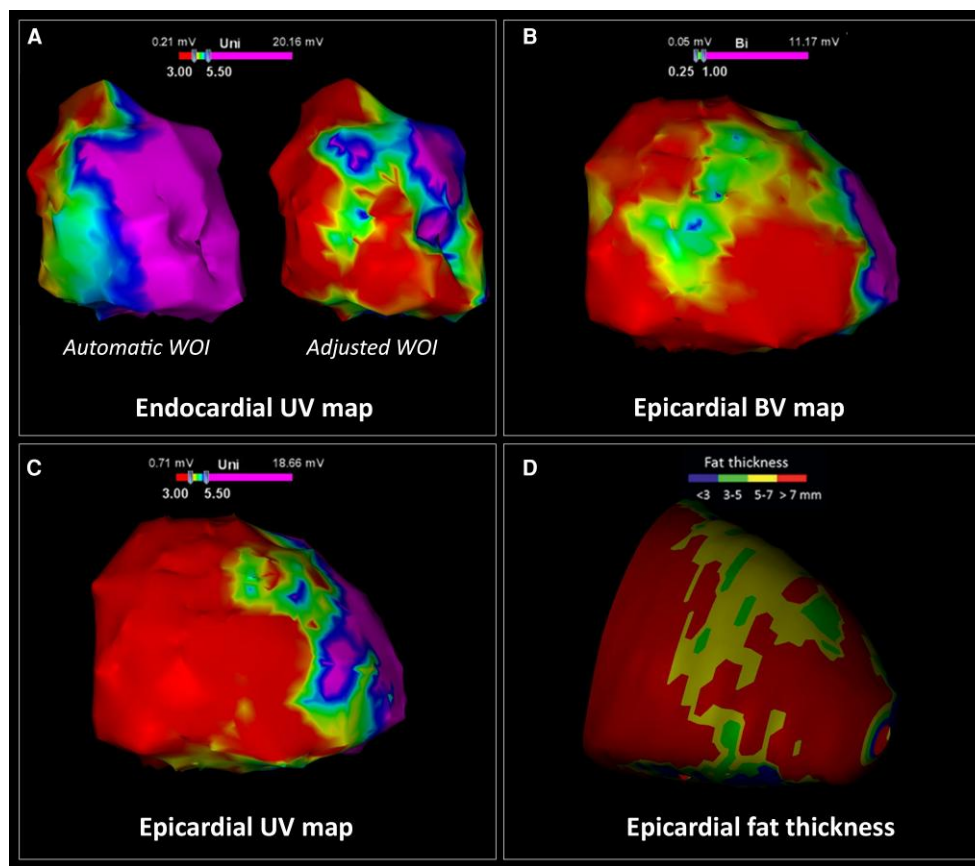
Example of the importance of adjusting the WOI and the role of epicardial UV mapping. Endocardial and epicardial mapping during RV pacing in a patient with arrhythmogenic right ventricular cardiomyopathy in modified right anterior oblique view. (A) Endocardial UV map using the automatic WOI on the left and the UV map after adjusting the WOI on the right, clearly demonstrating the underestimation of scar using the automatic WOI. (B) Epicardial BV map. (C) Adjusted epicardial UV map. (D) Epicardial FT map, based on CT. Notable, UV (see C) is less influenced by the thick epicardial fat layer at the apex, compared with BV (see B). BV, bipolar voltage; CT, computed tomography; FT, fat thickness; UV, unipolar voltage; WOI, window-of-interest.
